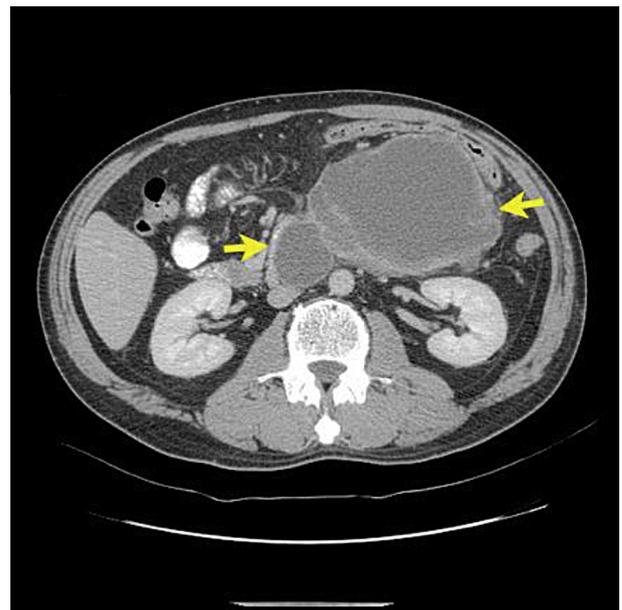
Abdominal computed tomography demonstrates a 14-cm heterogeneous hypodense mass in the body and tail of the pancreas, situated behind the stomach and next to the spleen and transverse colon (arrows).
